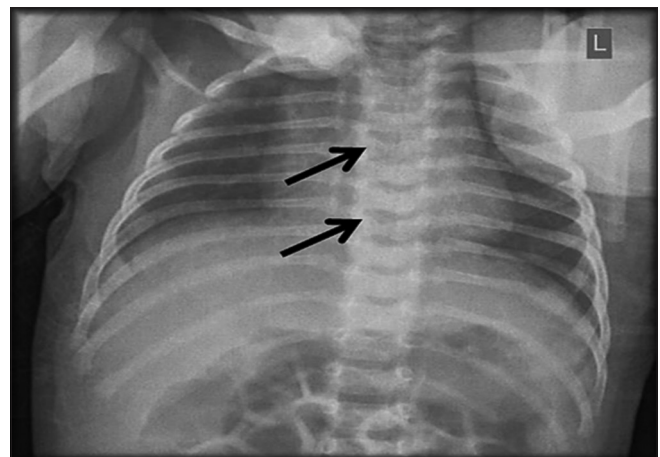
Chest X-ray of patient 2 showing butterfly vertebrae (arrows)
